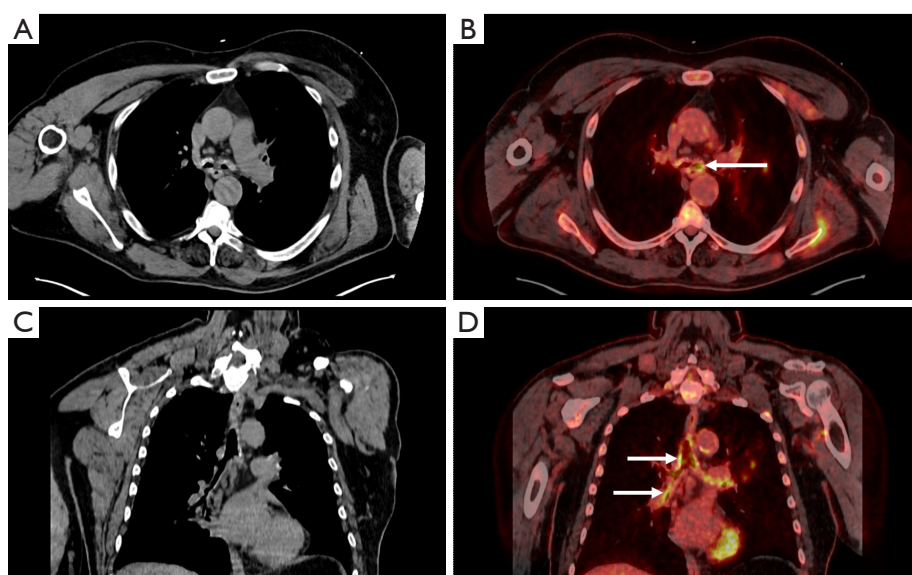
Tracheobronchial hypermetabolism during RP. Thoracic CT scan (A) related to 18-FDG PET scan (B) transverse section showing bronchial wall hypermetabolism (arrow). Thoracic CT scan (C) related to 18-FDG PET-CT (D) coronal section showing tracheobronchial wall hypermetabolism (arrows). RP, relapsing polychondritis; CT, computed tomography; 18-FDG, 18-fluorodesoxyglucose; PET, positron emission tomography.
